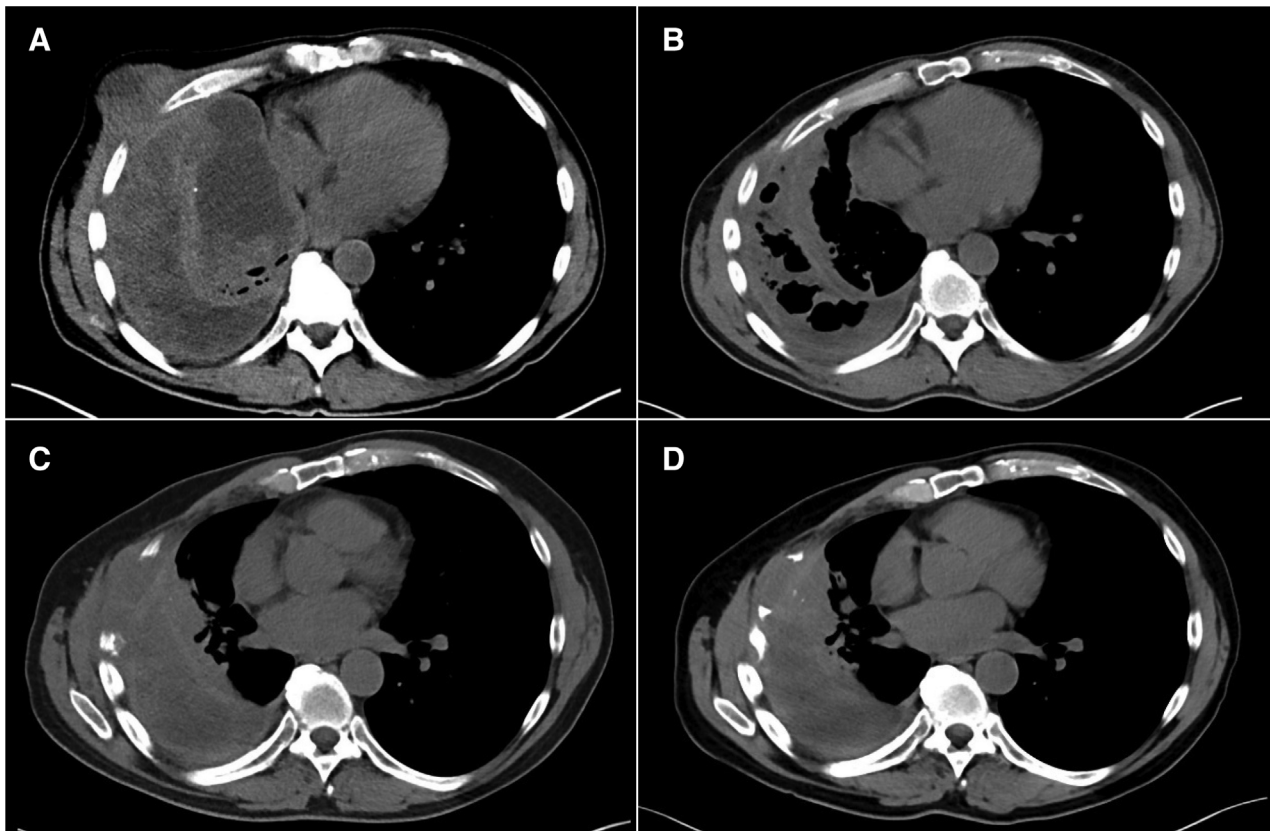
Progression of large metastatic pulmonary myxofibrosarcoma mass on computed tomography scans without contrast. (A): Depicting progression of disease after two cycles of trabectedin with 11.4 × 9.7 cm mass extending through the chest wall. (B): After two cycles of temozolomide (TMZ) with marked decrease in soft tissue component of lesion. (C): Recurrence of disease after 43 cycles of TMZ with a 7.6 × 1.8 × 4.4 cm mass resulting in destruction of adjacent ribs. (D): Stable to slightly decreased size of pulmonary mass after 16 cycles of atezolizumab.
